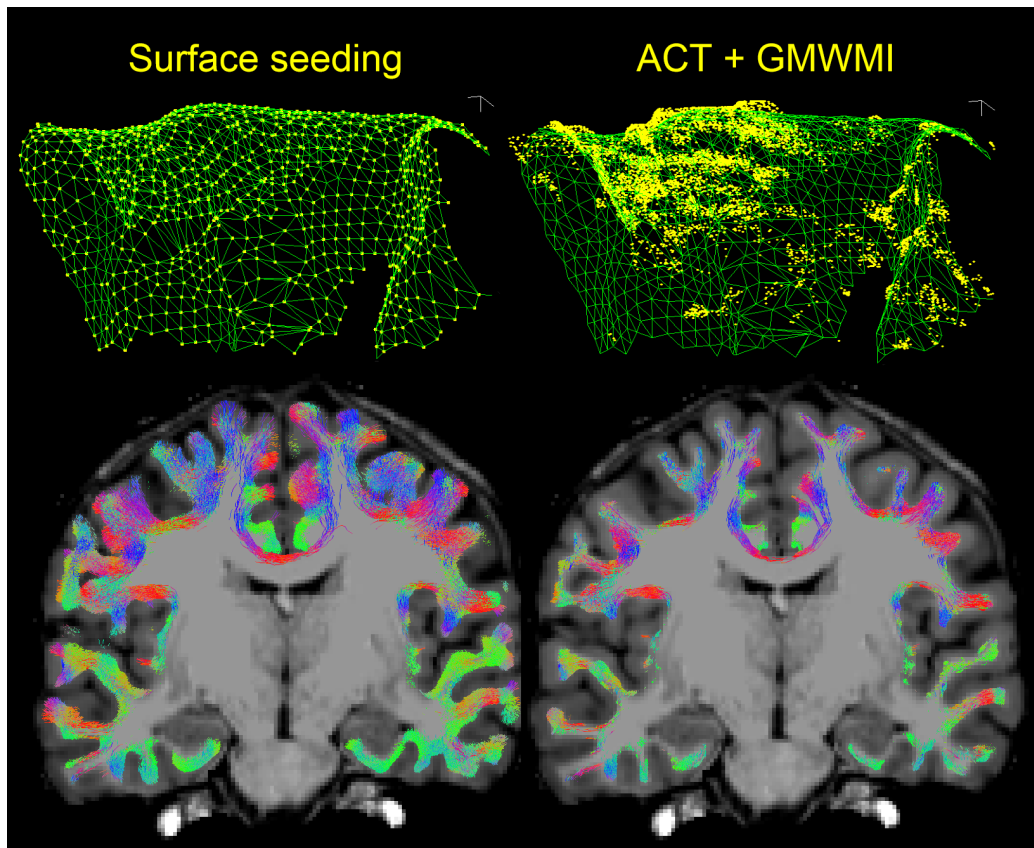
Tracking from the surface vertices (left) versus tracking using MRtrix ACT/GMWMI (right). Top row: distribution of seeding coordinates with each method (yellow) related to a section of the WSM (green), white lines show scale (1 mm) in three orthogonal directions. Surface seeding appears to achieve a more spatially uniform distribution and places seeds directly on the mesh (by definition). Bottom row: results of GG-filtering for both seeding methods (not truncated) overlaid on the T1-weighted volume (slice thickness: 1 mm). Surface-seeded streamlines extend into the grey matter, allowing to interface with the WSM.
